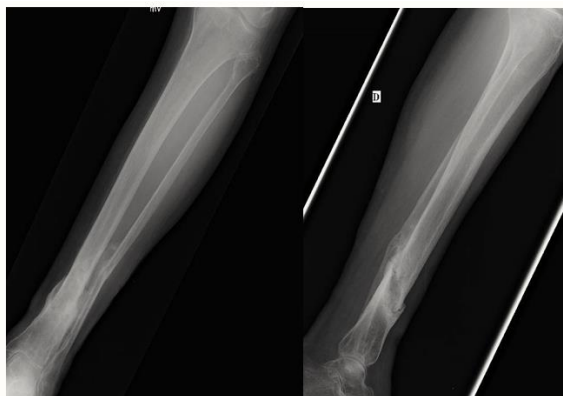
X-Ray after 8 months
